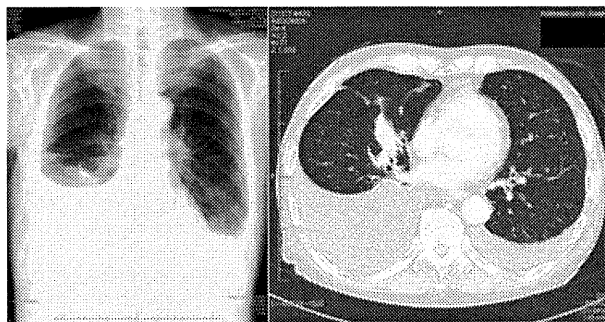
Bilateral pleural effusion. X-ray and computed tomography scans of the chest show bilateral pleural effusion.
